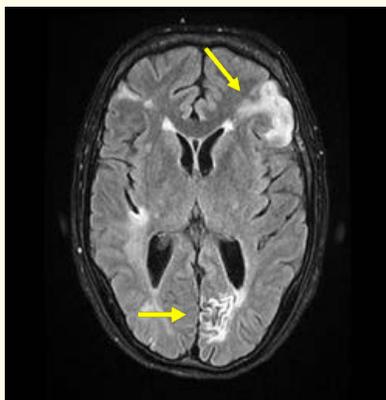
MRI showing recent infarction of the left frontal lobe and a chronic infarction of the left occipital lobe.
